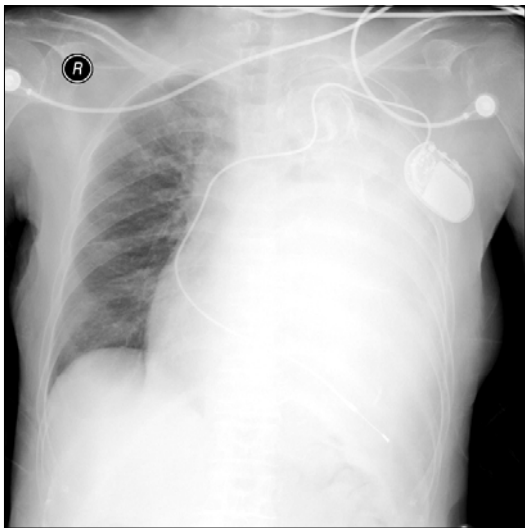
Chest X-ray prior to chest drain insertion. Dense opacification of the left hemithorax without mediastinal shifting is shown. The tip of the pacemaker lead in the right ventricle was found at the far left of the hemithorax and the heart silhouette is not clearly visible.
